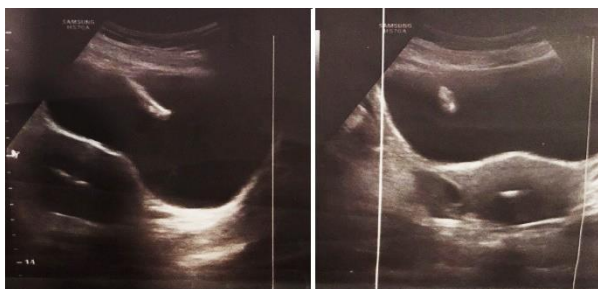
Ultrasound image showing IUD in uterus and bladder
